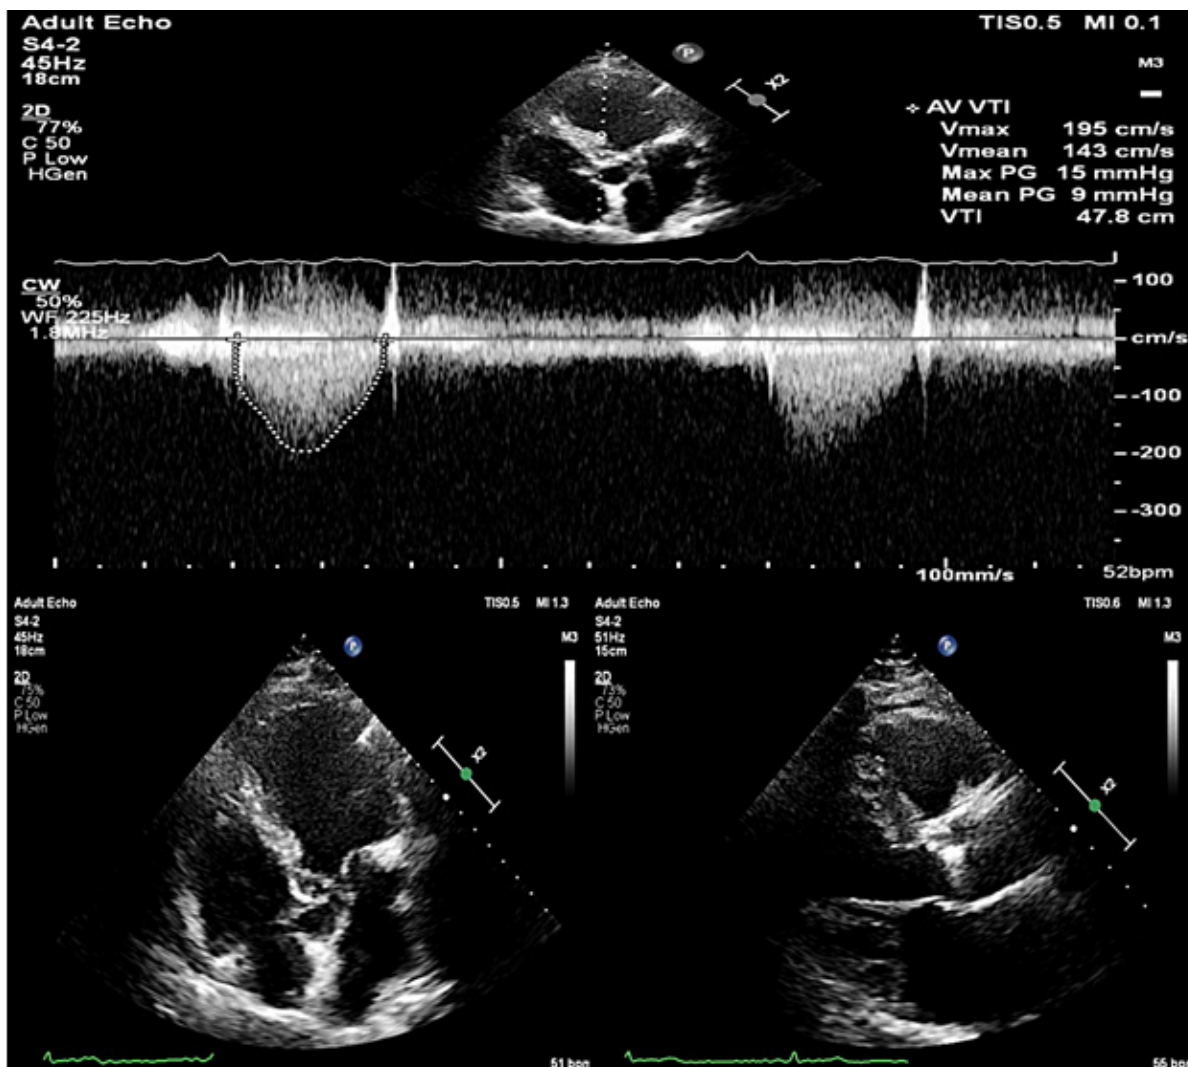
Echocardiographic image demonstrating aortic valve sclerosis and its determination in a patient
